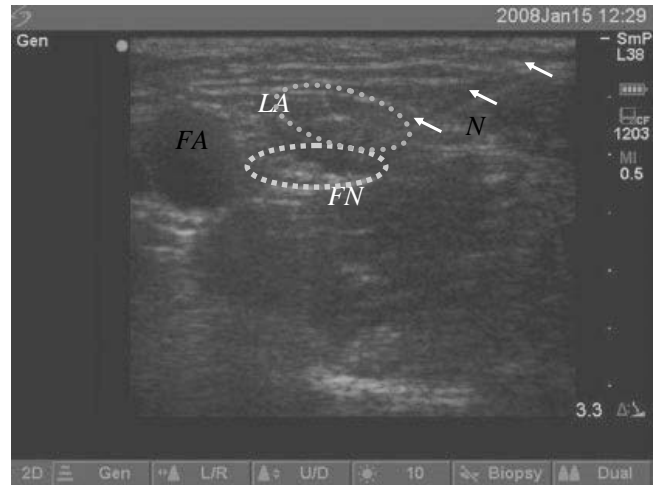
• Ultrasound-Guided Femoral Nerve Block. The image shows the performance of a femoral nerve block with needle visible in the long axis of the ultrasound beam. FN, femoral nerve; FA, femoral artery; N, needle; LA, local anesthetic (test dose, 0.5 mL).
